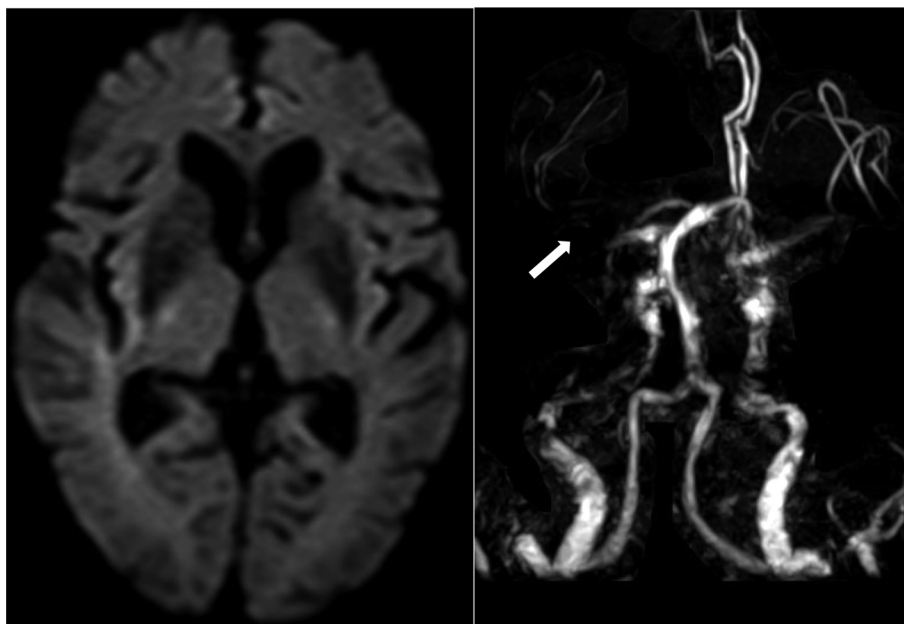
Magnetic resonance imaging (MRI) scan results at the first hospital. Left: Diffusion-weighted axial image. Right: Magnetic resonance angiography. MRI revealed no abnormal intensities on diffusion-weighted imaging (DWI); however, occlusion or severe stenosis of the right middle cerebral artery (M1 portion) was suspected (arrow).
